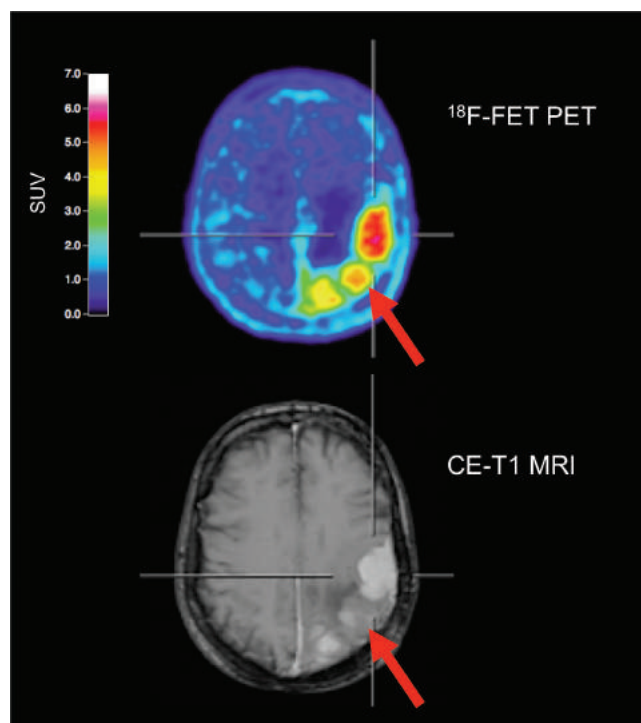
Amino acid PET with ^{18}F -FET and contrast-enhanced MR images of a 68-year-old female meningioma patient (WHO grade I) with suspected recurrence 9 years after tumor resection at initial diagnosis. ^{18}F -FET PET identifies 3 hypermetabolic lesions, consistent with meningioma recurrence. In contrast, MRI shows prominent contrast enhancement in only 2 of 3 lesions. In that lesion (arrow, bottom), contrast enhancement is subtle and not well defined. ^{18}F -FET PET allows an improved delineation of this lesion (arrow, top).
